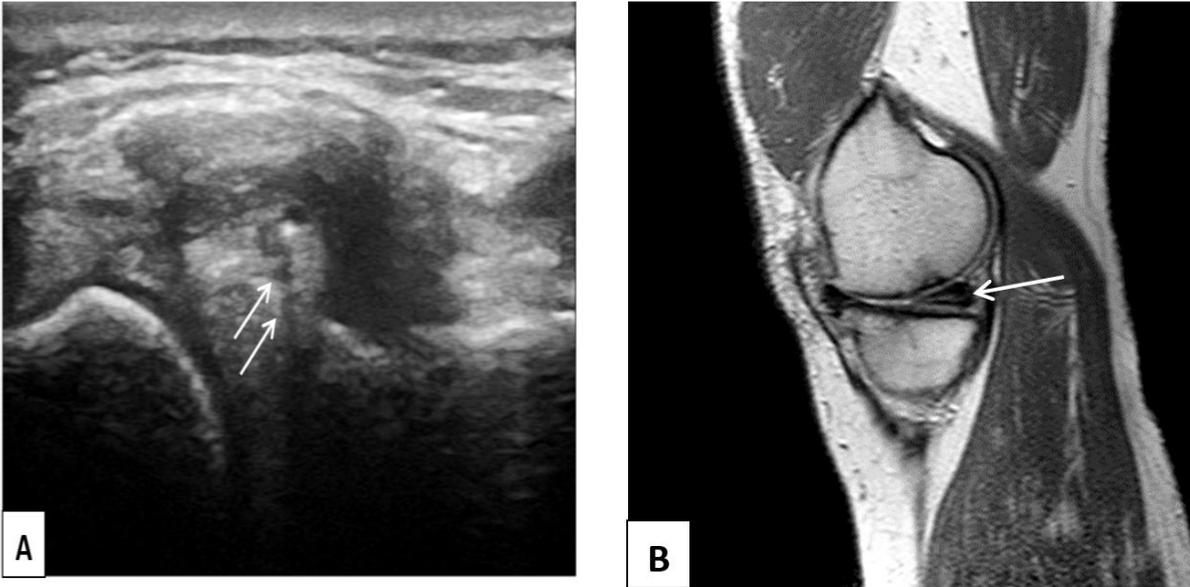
Ultrasound [A] and MRI [B and C] images of a 50 years old male, showing horizontal degenerative tear of the PHMM, with medial collateral bursa
